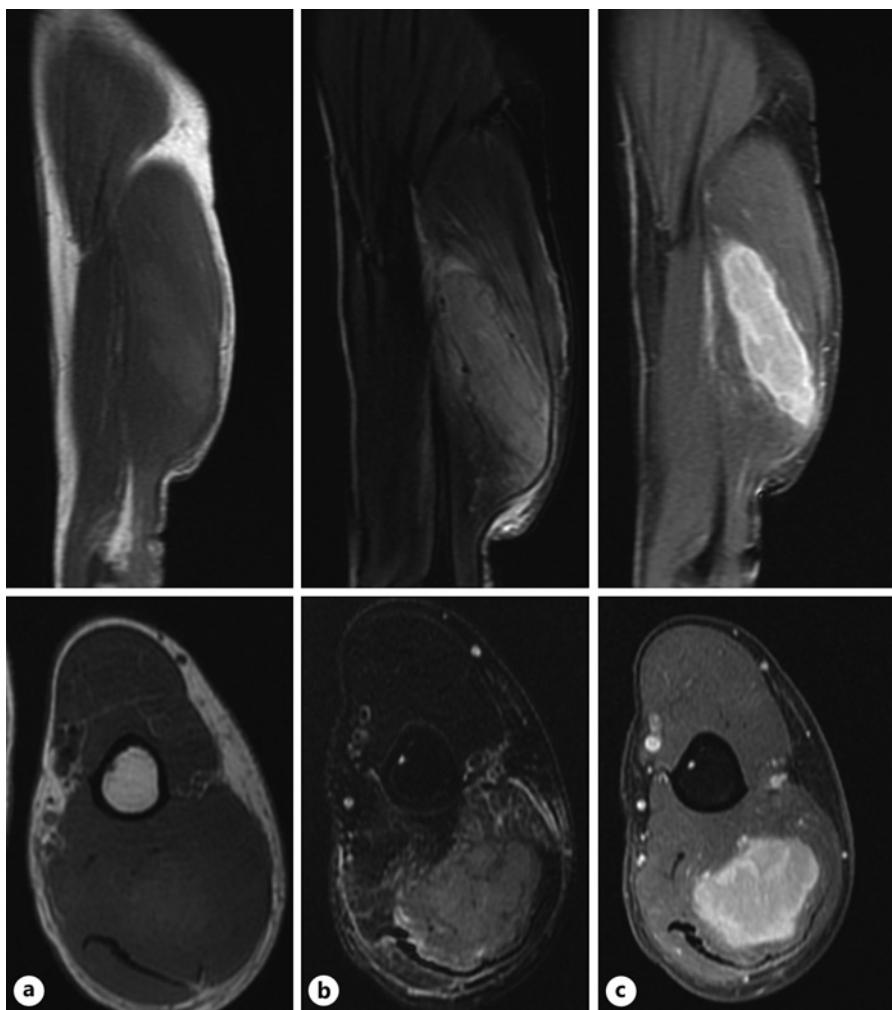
MRI findings of an intramuscular mass in the left upper arm. Images show a 9-cm-long mass in the lateral head of the triceps with iso-intensity on T1-weighted images (a), heterogeneously high intensity on T2-weighted images with fat suppression (b), and strong enhancement with gadolinium (c).
